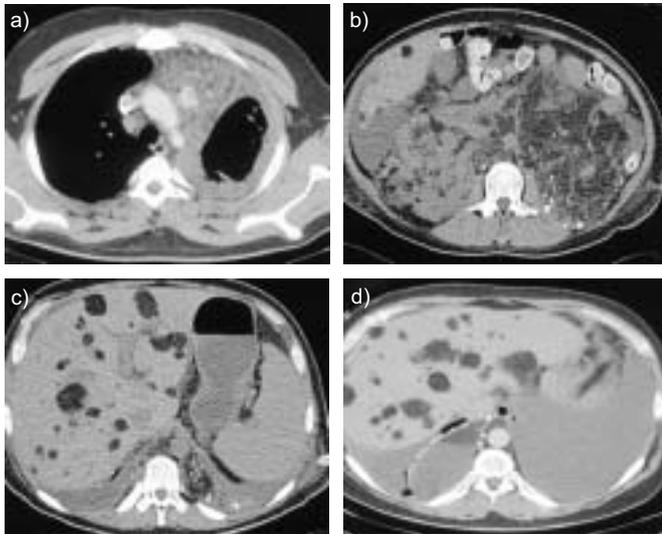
Computed tomography (CT) scans of the patient immediately prior to resection of the second mediastinal angiomyolipoma. a) With *i.v.* contrast in the mediastinal vessels, the anterior mediastinum is filled out with fat- and soft tissue-equivalent, inhomogenous masses, which broaden the mediastinum. Additionally, pleural thickening and effusions are apparent, including focal callosities with accentuation of the left side. b and c) Abdominal scans demonstrate multiple, hypodense and fat-equivalent hepatic lesions. Additionally, an extensive mass showing the same CT appearance is apparent in the left retroperitoneum. d) The intra-abdominal white spots represent inclusions of contrast agents following lymphography. However, the basal lung scans do not reveal any tumour manifestation, thereby implying that a continuous tumour extension from the retroperitoneum to the mediastinum is rather unlikely.
